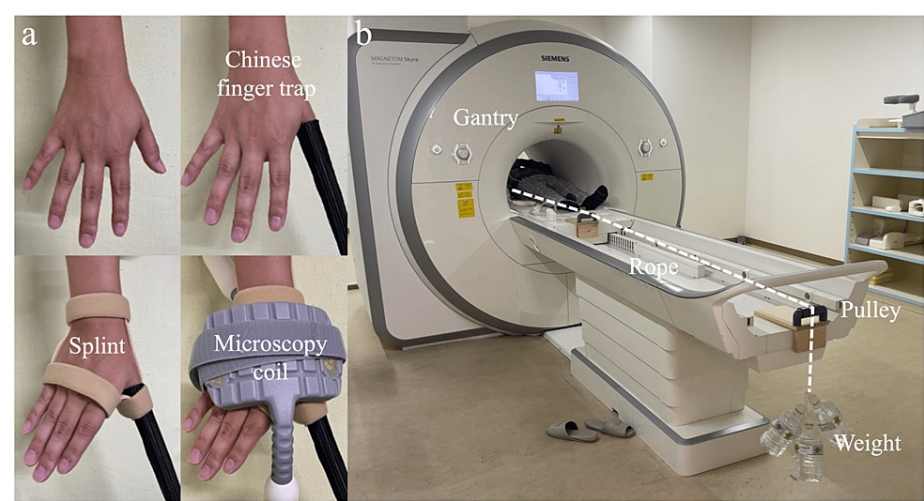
Application of axial traction during thumb carpometacarpal joint MRI
